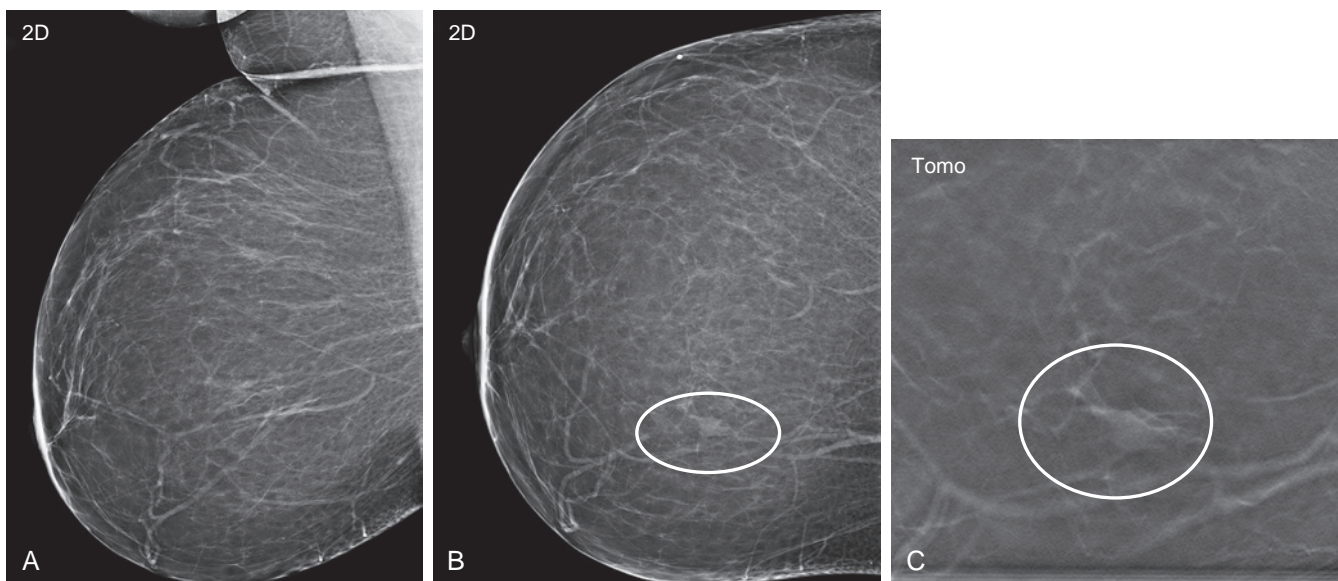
Asymmetry representing normal tissue. A 41-year-old woman presented for baseline screening mammogram. (A) Right 2D mediolateral oblique view demonstrates no suspicious finding. (B) An asymmetry (*oval*) is seen in the medial right breast on cranio-caudal view only on 2D image. (C) At the time of recall, a single-combination, 2D-tomosynthesis, spot compression view was performed that redemonstrates the asymmetry on tomosynthesis (*oval*). Tomosynthesis images localized the finding in question to the upper inner breast, and targeted ultrasound was performed. No sonographic correlate was identified. The asymmetry was thought to represent fibroglandular tissue, and the finding was stable on a follow-up mammogram of the right breast in 6 months.
